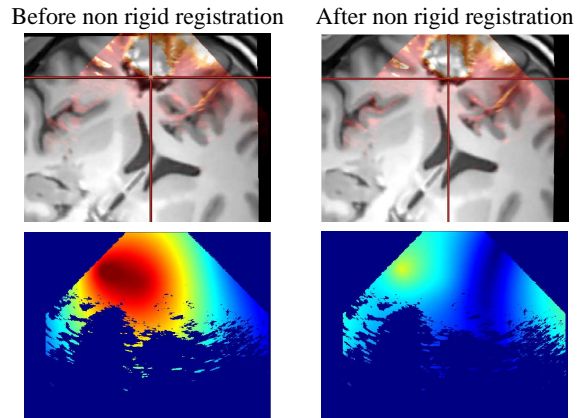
Synthetic deformation. Top : Overlay of the denoised US and the resliced MR images before and after non rigid registration. Bottom : Distance norm between the US and MR images before and after non rigid registration.
